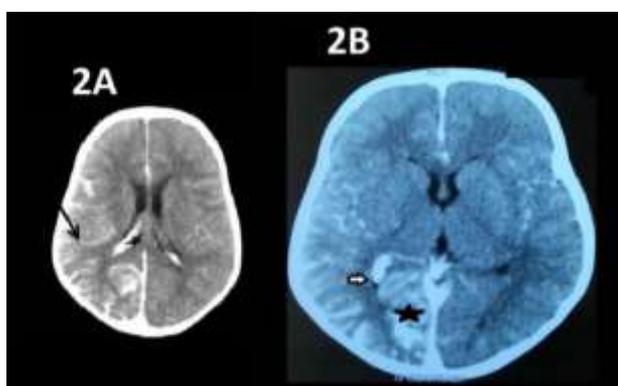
Contrast enhanced CT scan shows extensive pial enhancement in right parieto-occipital lobe (as shown with arrow) and ipsilateral enlargement of choroid plexus (as shown with star). Fig. 2B: Contrast enhanced CT scan shows ipsilateral enlargement of choroid plexus (as shown with star)
